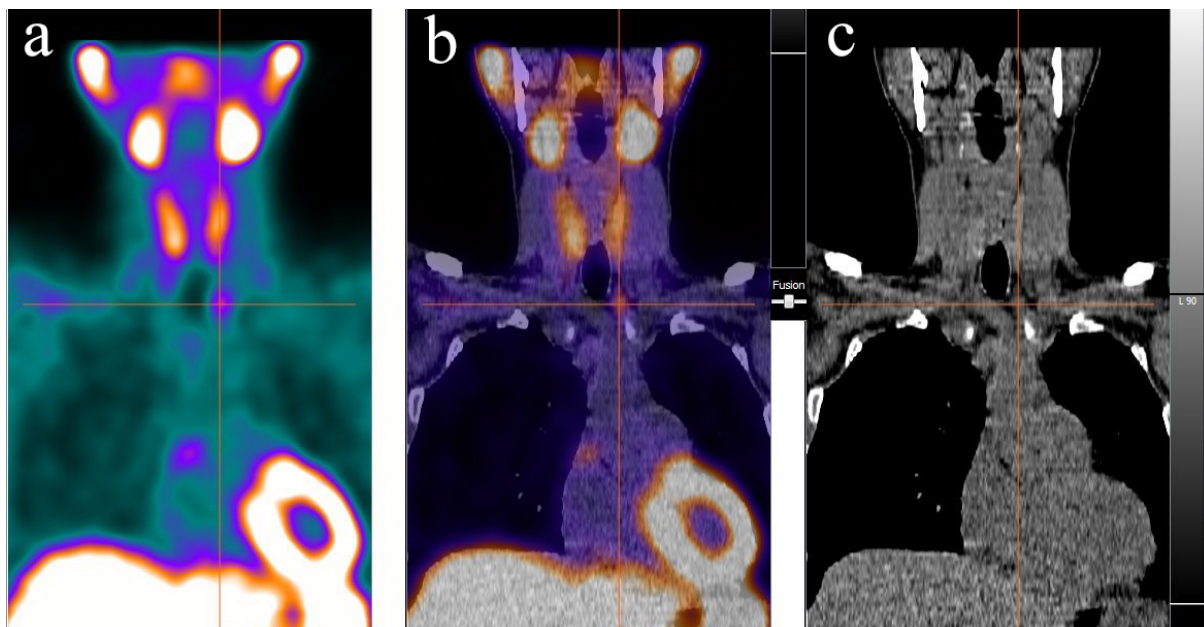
Case 3: Coronal view: The scintigraphic shows the presence of parathyroid/hyperplastic tissue in the left paratracheal site behind the medial margin of the clavicle. (a) Scintigraphic acquisition phase. (b) Multimodal image fusion. (c) Non-contrast computed tomography phase.
